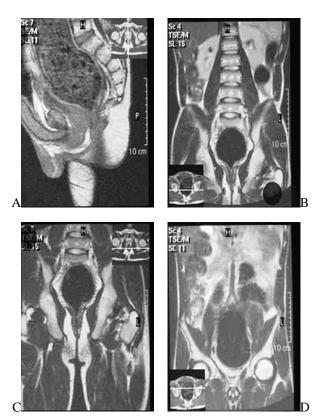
HD A: Sagittal cut by MRI showing the level of transition zone. B, C & D: Coronal cuts by MRI showing the level of transition zone.
